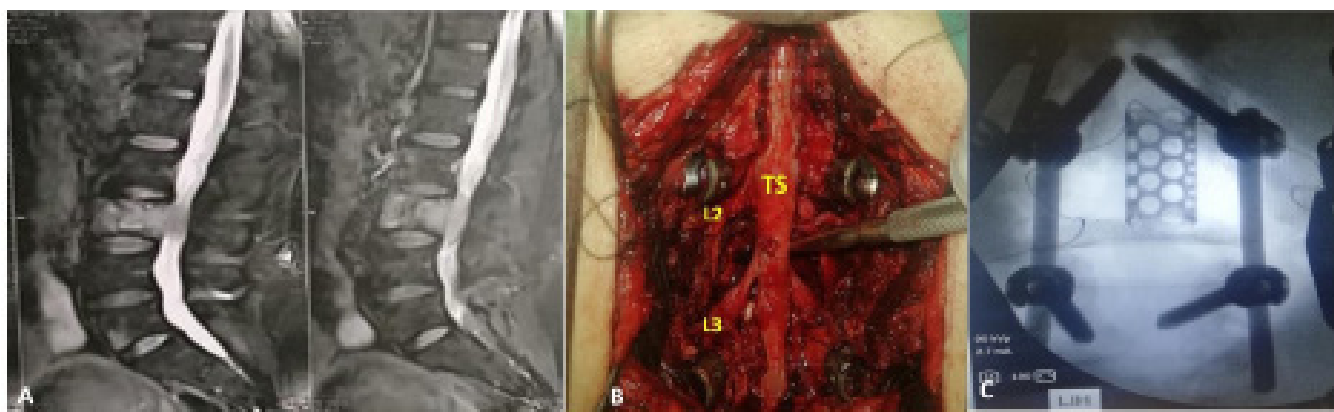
Case 2, (A): Preoperative MRI showing compression of cauda equina by L4 metastatic tumor, (B): Intraoperative picture showing removal of the tumor anterior to the thecal sac (TS), L2 and L3 roots were decompressed at both sides, (C): Intraoperative x-ray showed posterior VCR and insertion of mesh cage.
